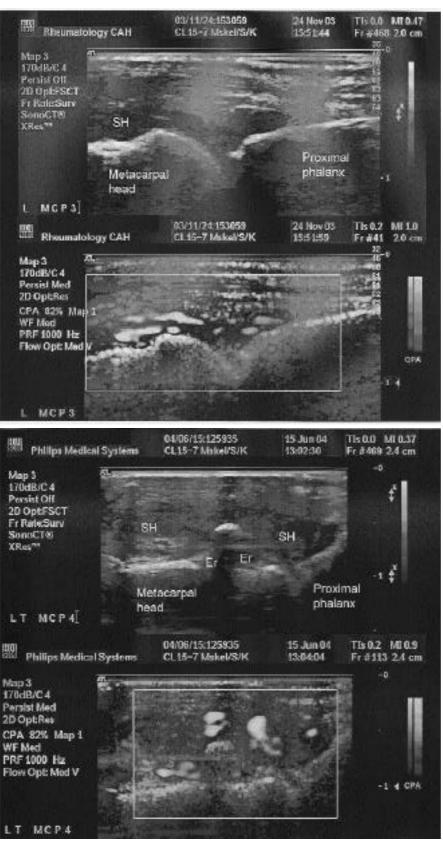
Musculoskeletal ultrasonography (MUS) images.
